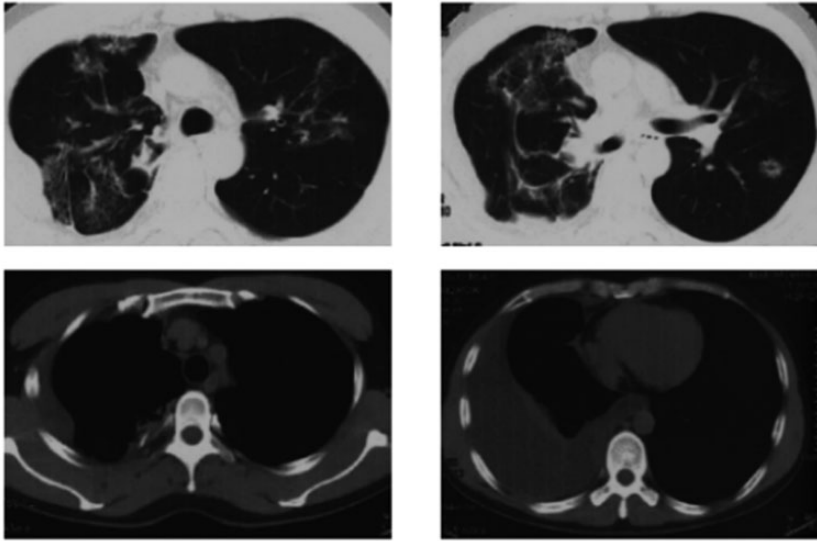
Chest computed tomography images undertaken in December 2015 after the patient accidentally contracted an upper respiratory tract infection at 7 months after surgery. The images show multiple interstitial lesions in both lungs, especially in the right lung, with localized emphysema and effusion in the right thoracic cavity.
